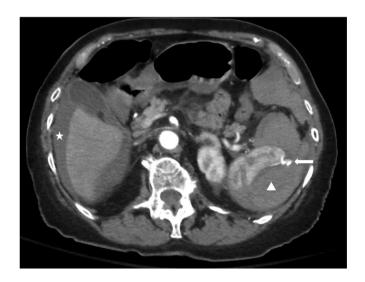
Computed tomography (CT) angiography demonstrating hemoperitoneum (white star), a large perisplenic hematoma (white triangle), with active extravasation of contrast from the inferior pole of the spleen (white arrow)
